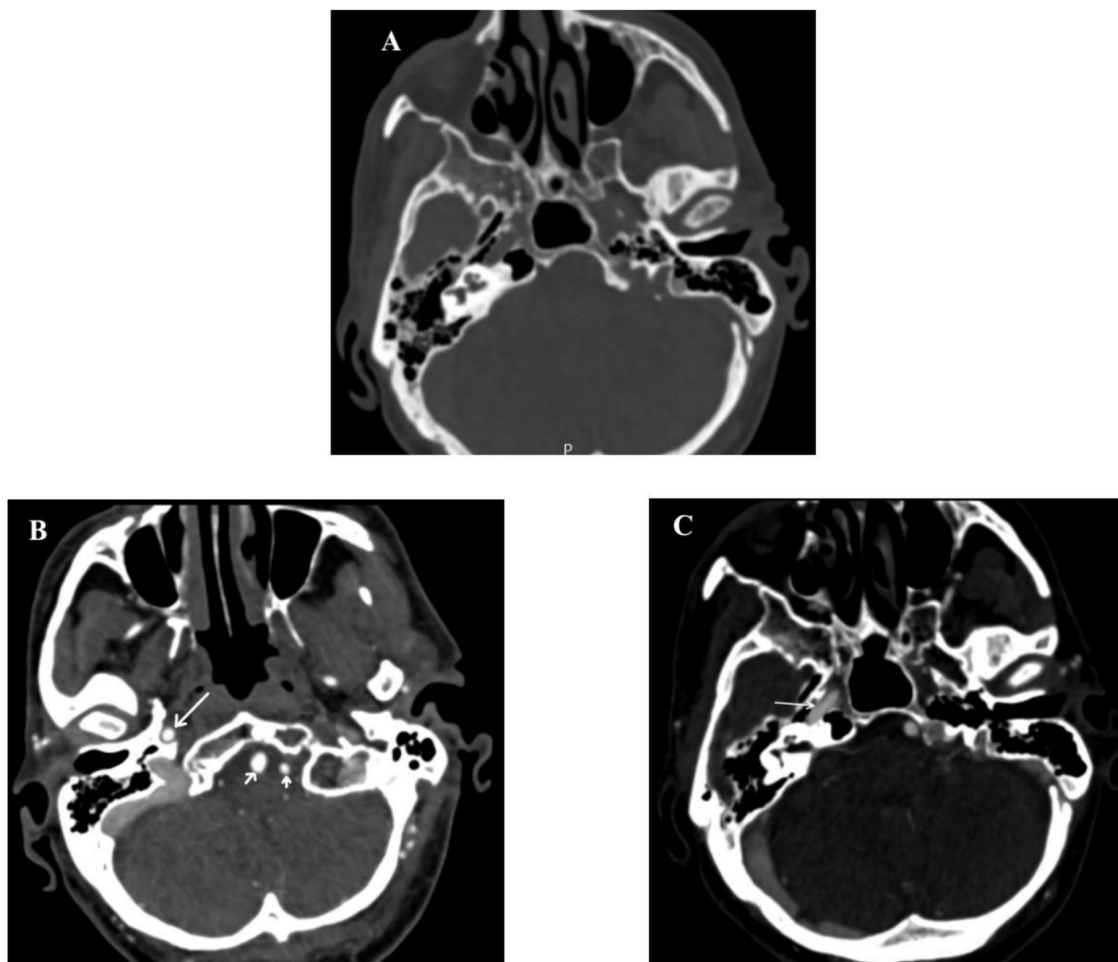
A: Non-enhanced axial CT image in case 1 shows the absence of the left petrous carotid canal within the skull base. B: Axial CT angiography image at the level of the skull base in case 1 shows the ICA (long arrow) and bilateral vertebral arteries (short arrows); however, the left ICA is absent. C: Just superiorly, the right ICA is present within its carotid canal (white arrow); however, the left ICA and left carotid canal are absent.
